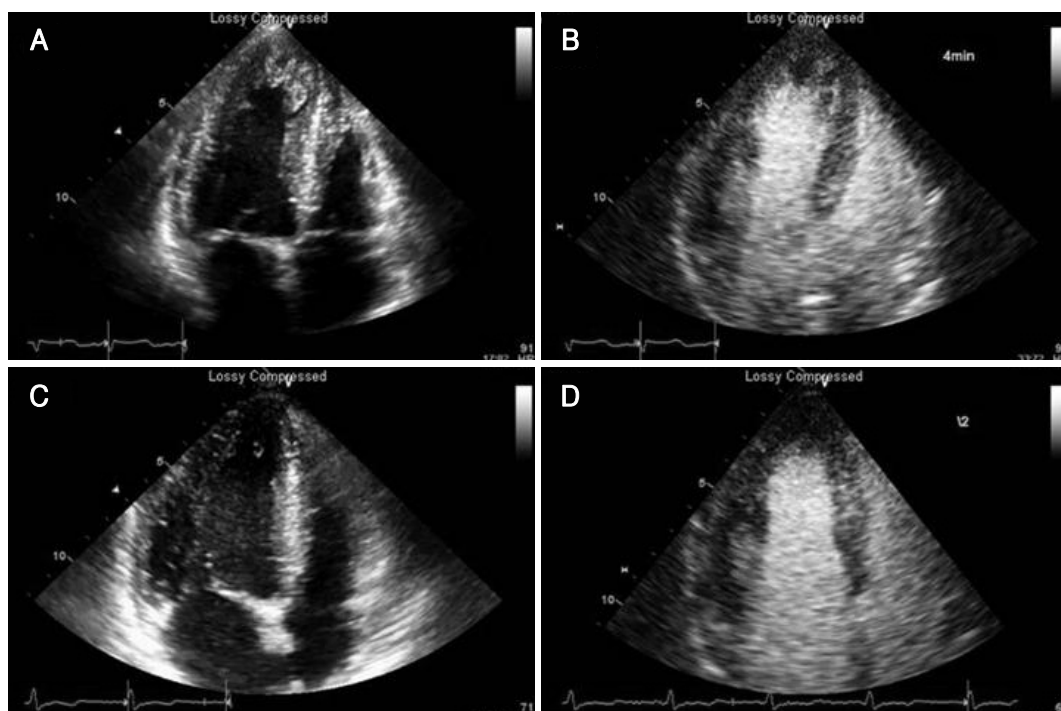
An apical thrombus of the left ventricle due to stress-induced cardiomyopathy. Two dimensional echocardiography shows an apical LV thrombus (A and B) and disappeared apical thrombus (C and D) after anticoagulant therapy.
